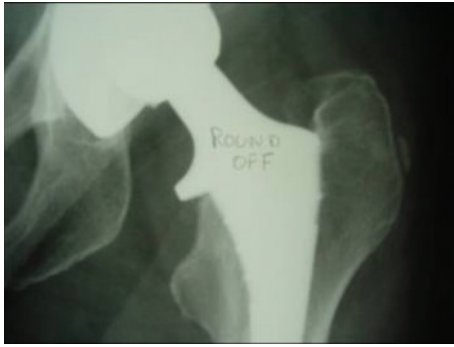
Radiograph showing calcar bone round-off to the junction of the collar and stem.
